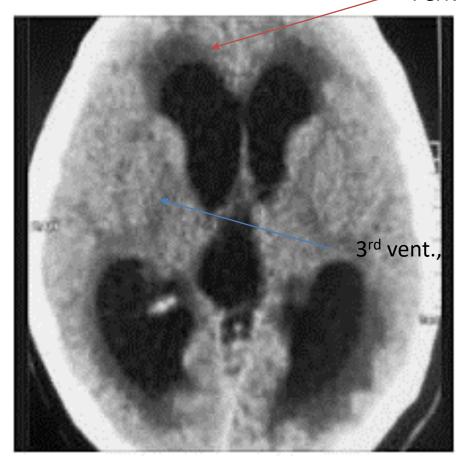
CT showing Congenital Hydrocephalus
